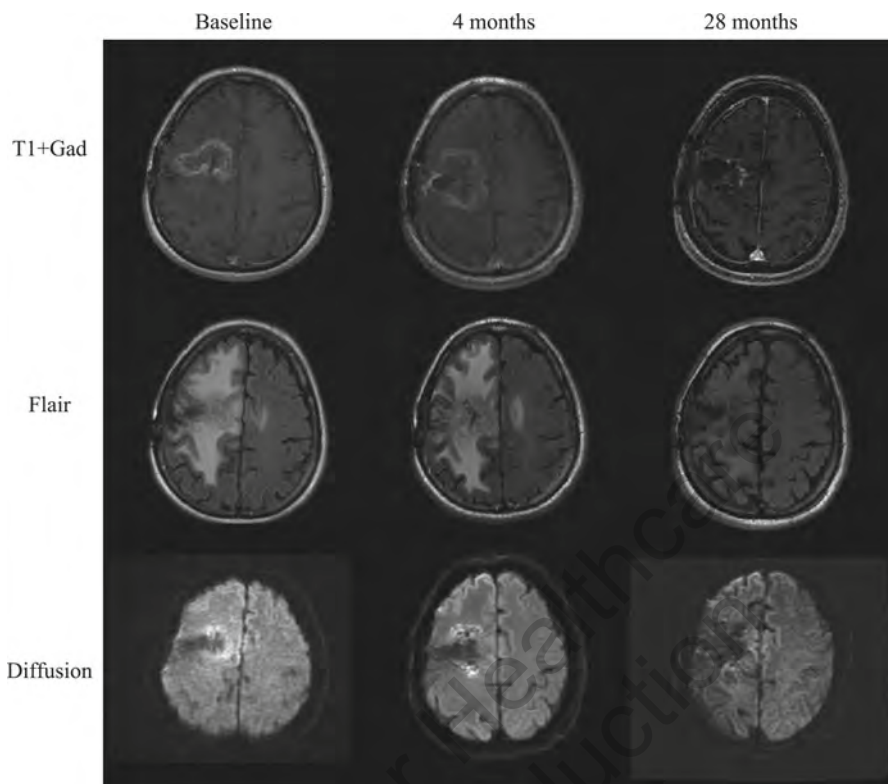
T1-weighted post-contrast with corresponding FLAIR and diffusion MR images of a heavily pretreated 48-year-old man with secondary GBM. The patient underwent 3 debulking surgeries, radiotherapy with concomitant daily temozolomide, as well as Gamma knife boost. The tumor showed heterozygous deletions of 1p and 19q chromosomes and methylated *MGMT* promoter. The patient was treated with TTFields for 28 months until radiological response was achieved and has been on treatment for 45 months thus far. Notably, the tumor grew during the first 8 months on treatment and only then began to decrease in size. Additional MRI sequences show that the initial tumor growth was accompanied by increased FLAIR signal but not increased diffusion signal. Vymazal et al. Response patterns of recurrent glioblastomas treated with tumor-treating fields. *Semin Oncol.* 41 Suppl 6:S14-S24, 2014. Elsevier
